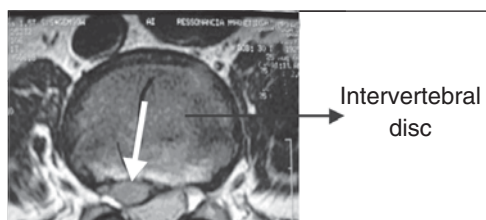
Nuclear magnetic resonance image, at axial plane, showing disc hernia (white arrow).
